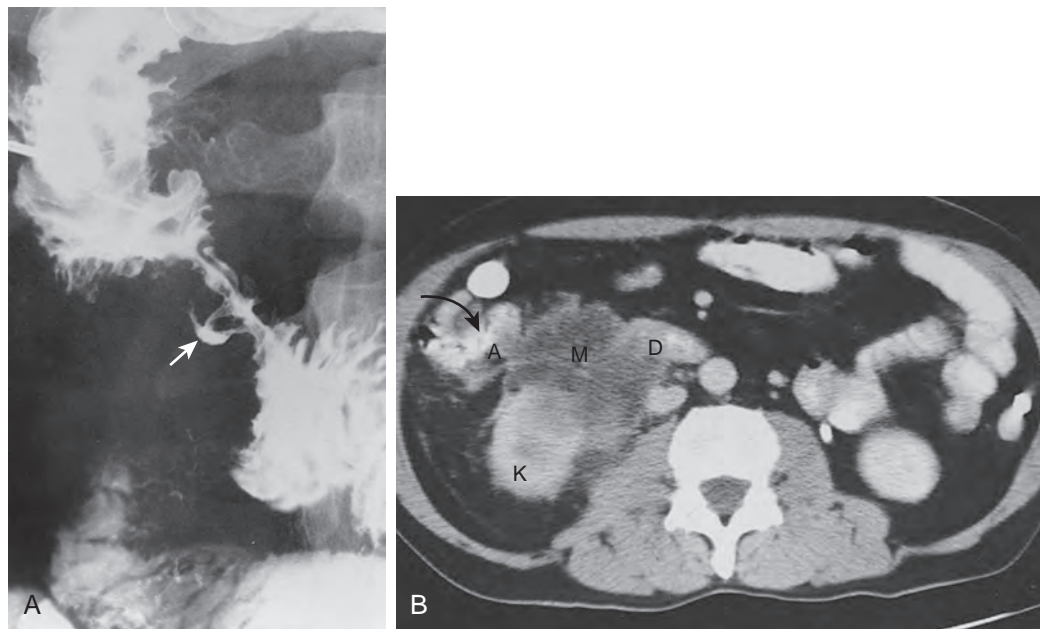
Duodenal invasion by colonic carcinoma. A. A large area of mass effect is seen on the lateral border of the descending duodenum with associated ulceration (*white arrow*). This finding was caused by carcinoma of the hepatic flexure invading the duodenum. B. In another patient, CT scan shows invasion of the duodenum by recurrent carcinoma arising from the region of an ileotransverse colonic anastomosis (A). A heterogeneous mass (M) is seen invading the duodenum (D) and right kidney (K). Contrast medium is present in the bowel (*black arrow*) adjacent to the anastomosis.
